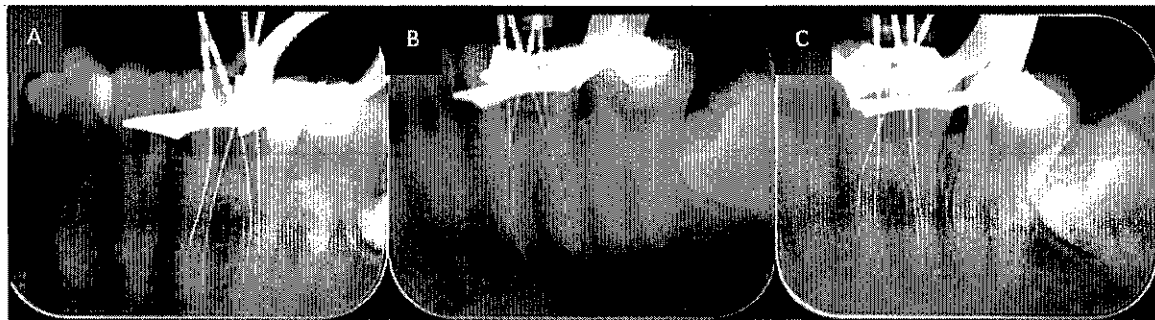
Representative acceptable and unacceptable radiographic images. Working length determination radiographs of a first mandibular molar (4 canals) taken at different angulations: A = +20°, B = 0°, C = -20°. Score = 1 (A and C), score = 0 (B).
